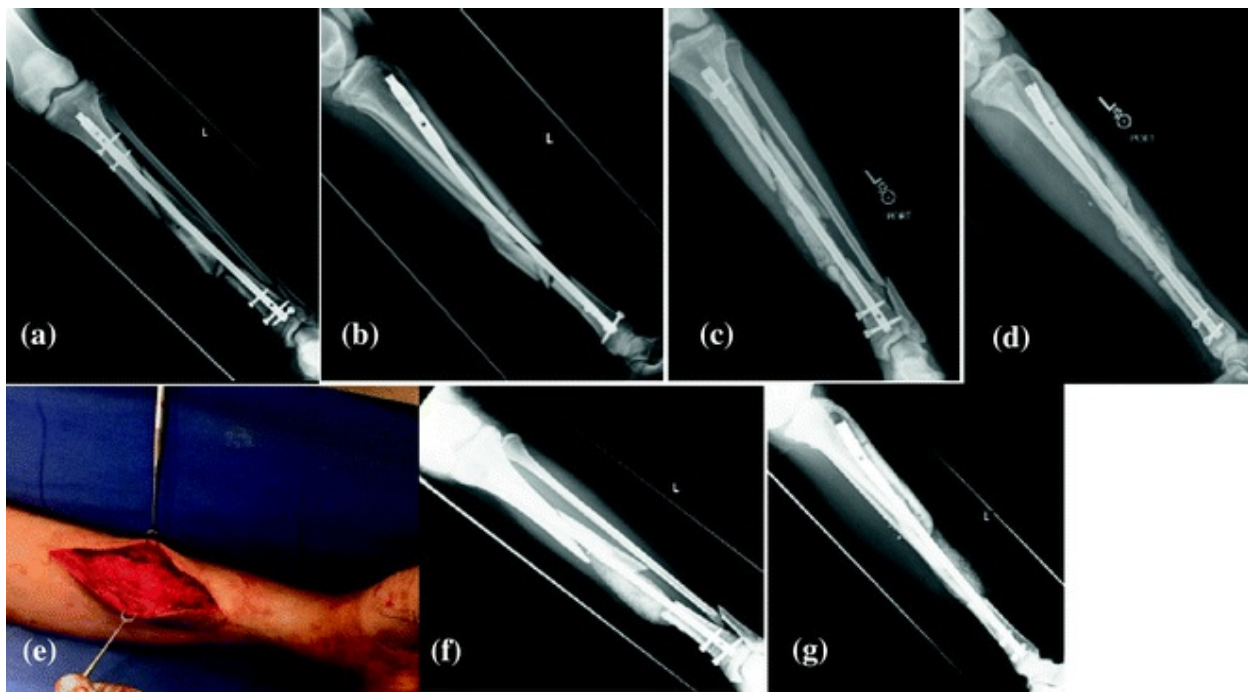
38-year-old female presented with a infected nonunion (a, b). Underwent debridement and placement of antibiotic cement spacer (c, d). Reamer-irrigator/aspirator performed at 8 weeks from ipsilateral femur. Bone grafting of the tibial defect (e). AP and lateral radiographs of tibia at 2 weeks
